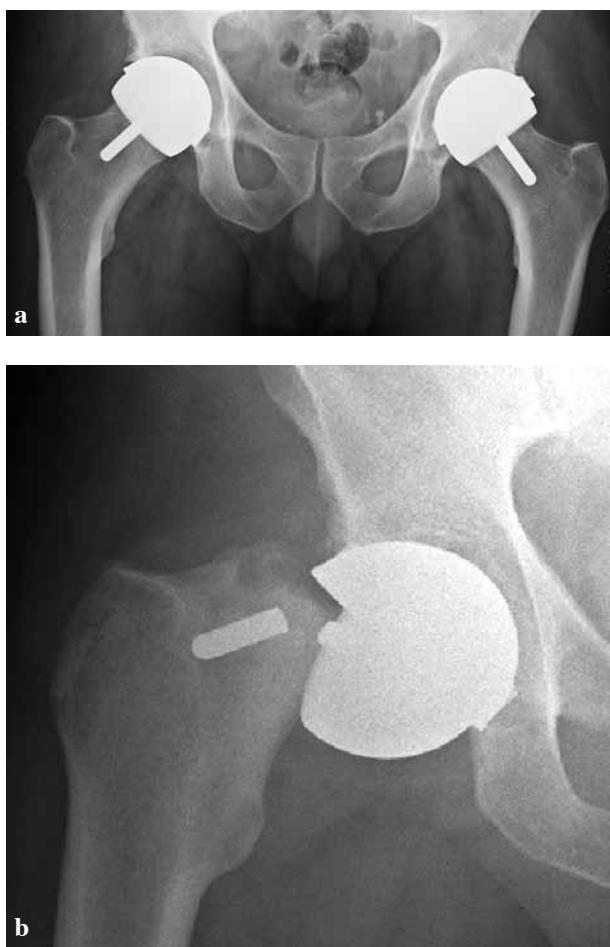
a) AP Pelvis radiograph. Demonstrating femoral stem in neutral alignment (lateral view not shown also confirms neutral alignment), b) Radiograph of femoral alignment stem fracture.
